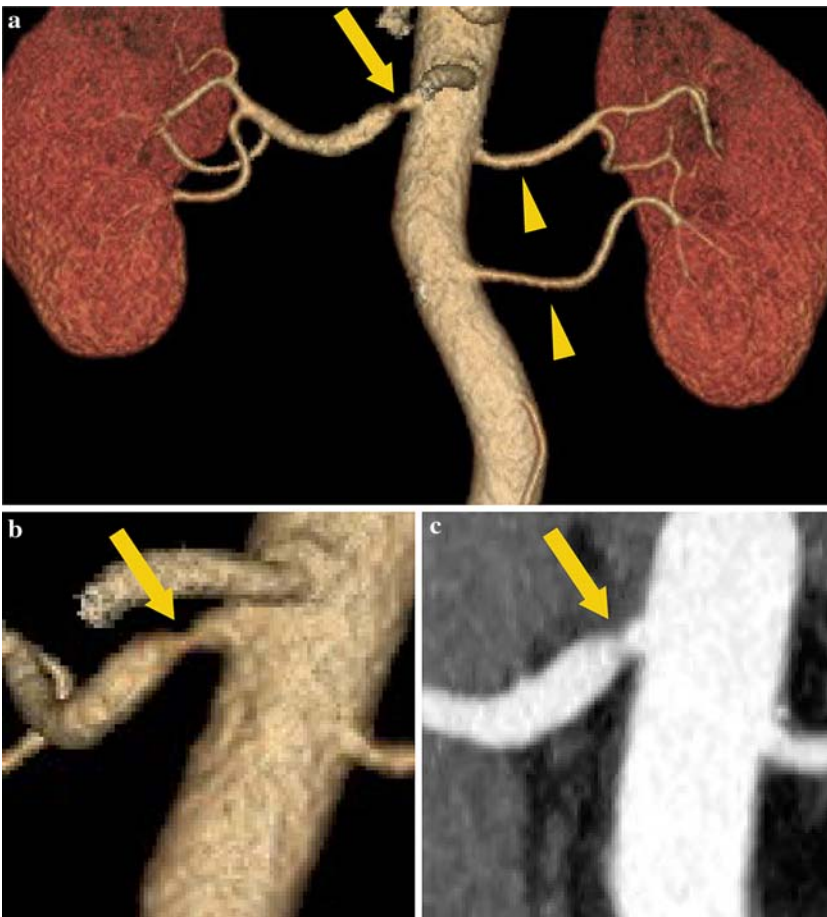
CTA of renal arterial stenosis. Volume-rendered (A and B) and MIP (C) images of the renal arteries demonstrate high grade stenosis at the origin of the single renal artery and two widely patent left renal arteries (*arrowheads*).
